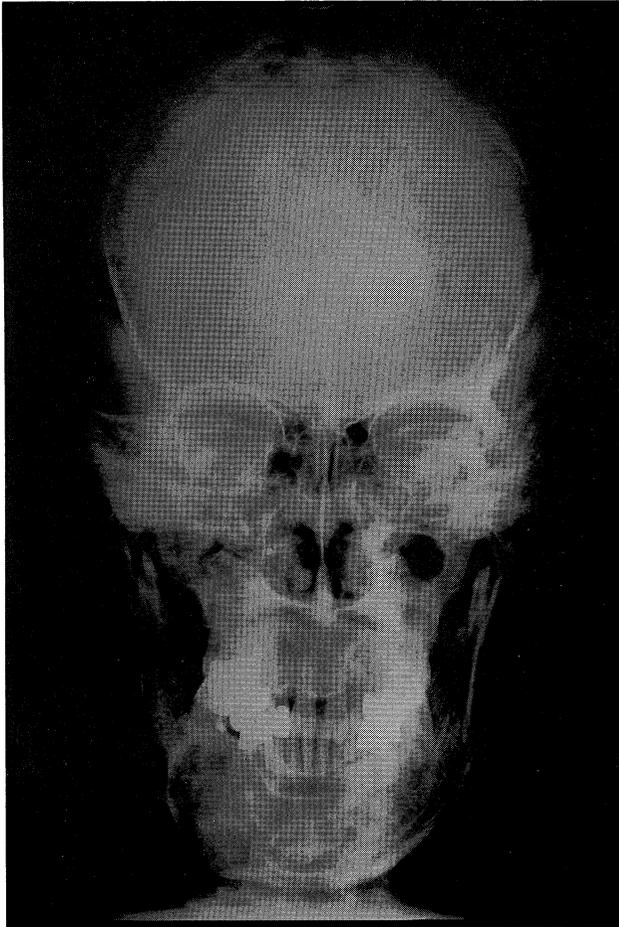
X-ray picture of the mandible.
